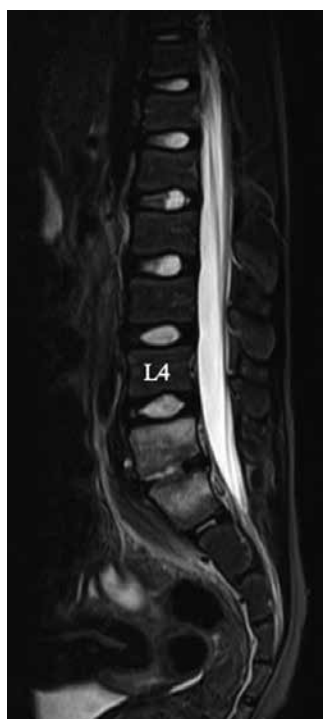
Initial image of the lumbar spine Short tau inversion recovery (STIR) sagittal images of preoperative MRI show high signal intensity in L5, S1 vertebral bodies and intervertebral disc space.
